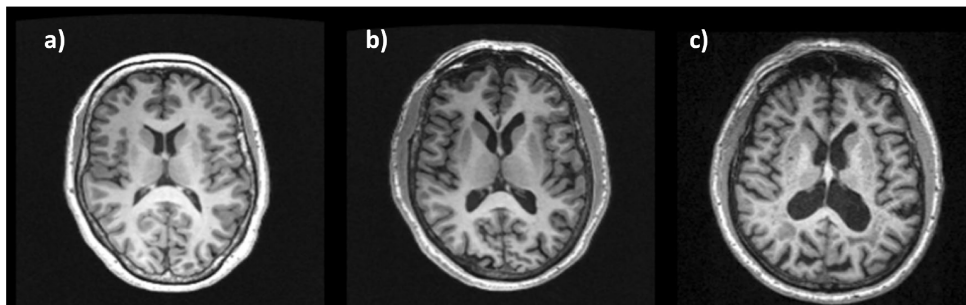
T1-weighted sMRI imaging showing decreased GM volume in an c) AD patient compared to a) healthy control and intermediate GM decline in b) patient with MCI [39].
